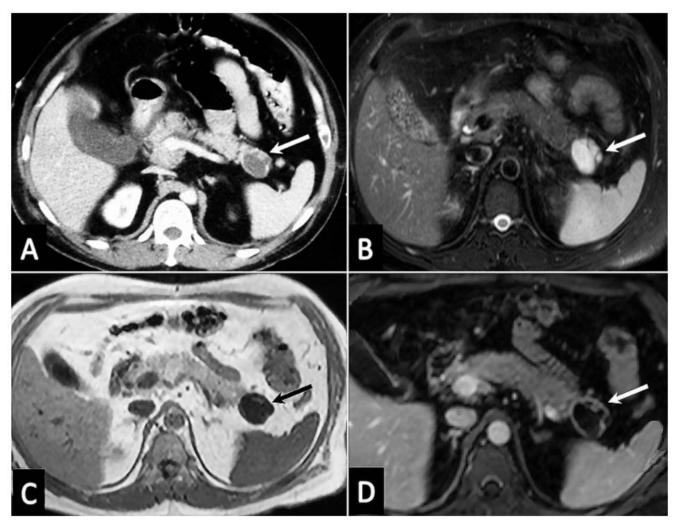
A – Axial contrast-enhanced computed tomography scan showing a cystic lesion in the tail of the pancreas (arrow) with a small mural nodule. Axial T2-weighted fat-saturated ($\bf B$), axial T1-weighted ($\bf C$), and axial contrast-enhanced ($\bf D$) magnetic resonance images showing a cystic lesion (arrow) in the tail of the pancreas with internal septations and a mural nodule.
